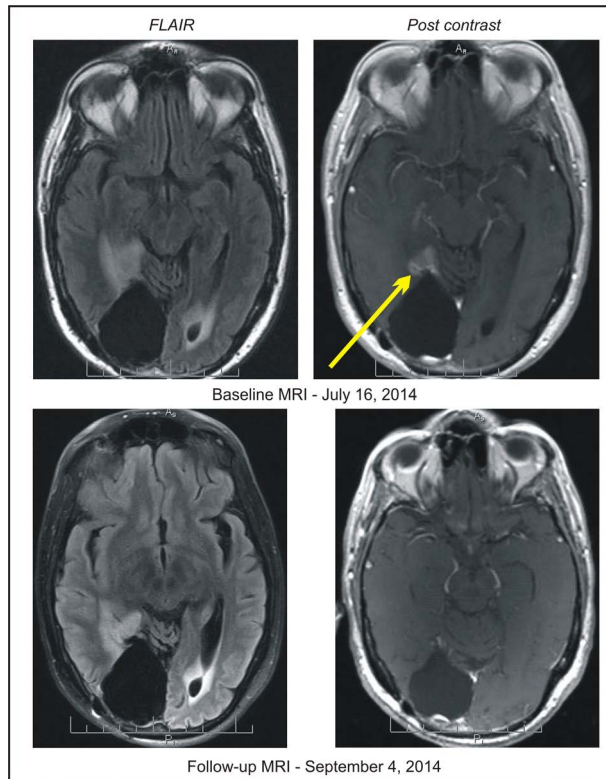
Patient 10, baseline and follow-up MRI of the head indicating complete response.
